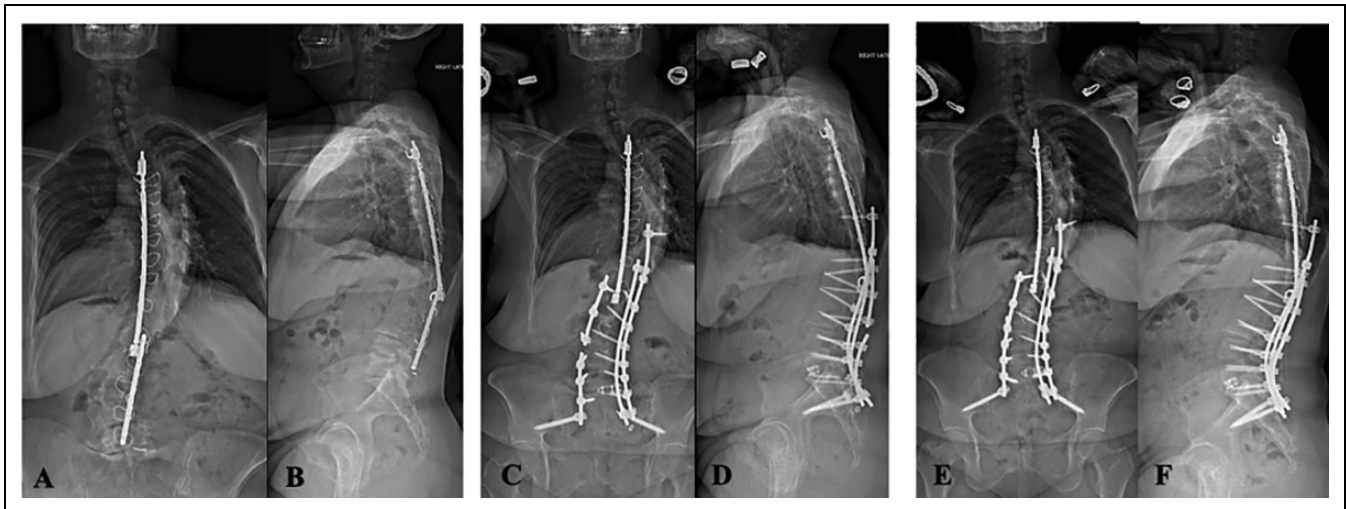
A 46-year-old female who presented with a weakness in her left ankle dorsiflexion and occasional right leg numbness with walking that had worsened over the past few months. On further questioning, she described that her right shoulder felt higher than the left shoulder and that she was increasingly pitched forward while standing. She had originally undergone Harrington rod instrumentation for adolescent idiopathic scoliosis at the age of 12. Preoperative anteroposterior (A) and lateral plain radiographs (B) of the full spine reveal fractured Harrington rod instrumentation with a caudal hook at L5 in the setting of significant loss of lordosis. Of note, a computed tomography scan showed pseudoarthrosis at L3-4 and L4-5 and a magnetic resonance imaging revealed foraminal narrowing secondary to residual scoliotic curve present at L5-S1, more severe on the left side. She subsequently underwent a removal of the caudal Harrington rod to effectively evaluate the fusion mass, in which revealed obvious pseudoarthrosis at L3-4 and L4-5. Next, in the same stage, she underwent posterior instrumentation from T10-pelvis with posterior column osteotomies performed at L3-4 and L4-5 and transforaminal lumbar interbody fusion at L5-S1 with restoration of her lumbar lordosis and maintenance of her overall sagittal alignment. However, at 6 months following surgery, she bent over forward to pick up an object and felt a “snap” in her back, followed by worsening low back pain. Anteroposterior and lateral plain radiographs of the full spine reveal a left rod fracture at L3-4 and a right S1 screw fracture (C, D). She subsequently underwent removal of the broken rod and screw and a revision T10-pelvis PSF (E, F). Of note, a gross pseudoarthrosis was encountered at L3-4 (the level of the broken rod).
